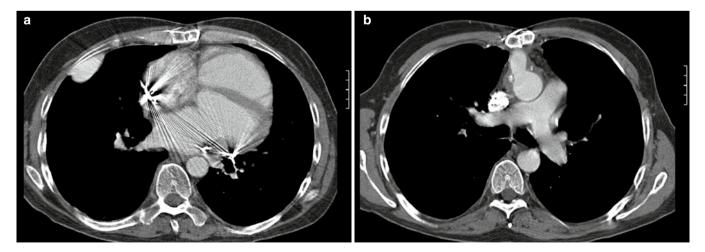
Pre-transplant CT scan of a patient with a Jarvik LVAD. (a) Mid-thoracic level demonstrating the outflow graft in right pleural space adjacent to chest wall. (b) Insertion of outflow graft into the aorta demonstrating that the graft lies immediately behind the sternum at this level and so is at risk during sternal reopening.
